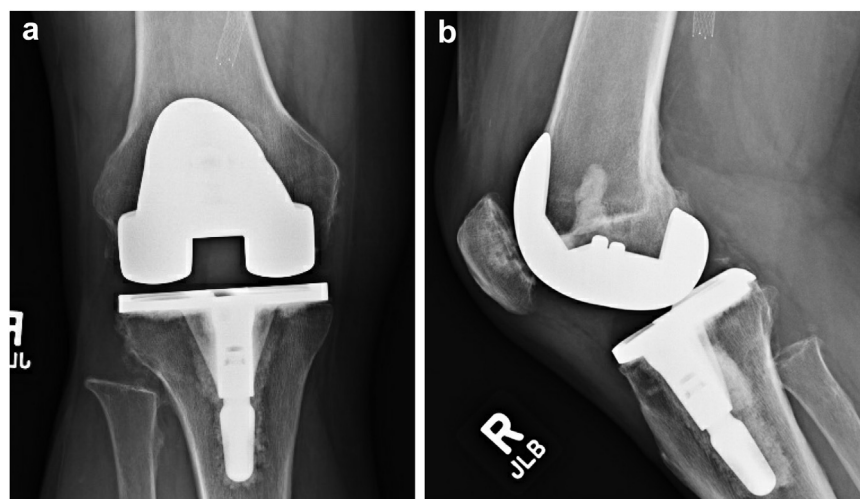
(a) Anteroposterior and (b) lateral plain radiographs of the knee at the most recent follow-up 3 years after the index procedure, showing a well-fixed total knee arthroplasty without signs of loosening, and the resected fibular head.
